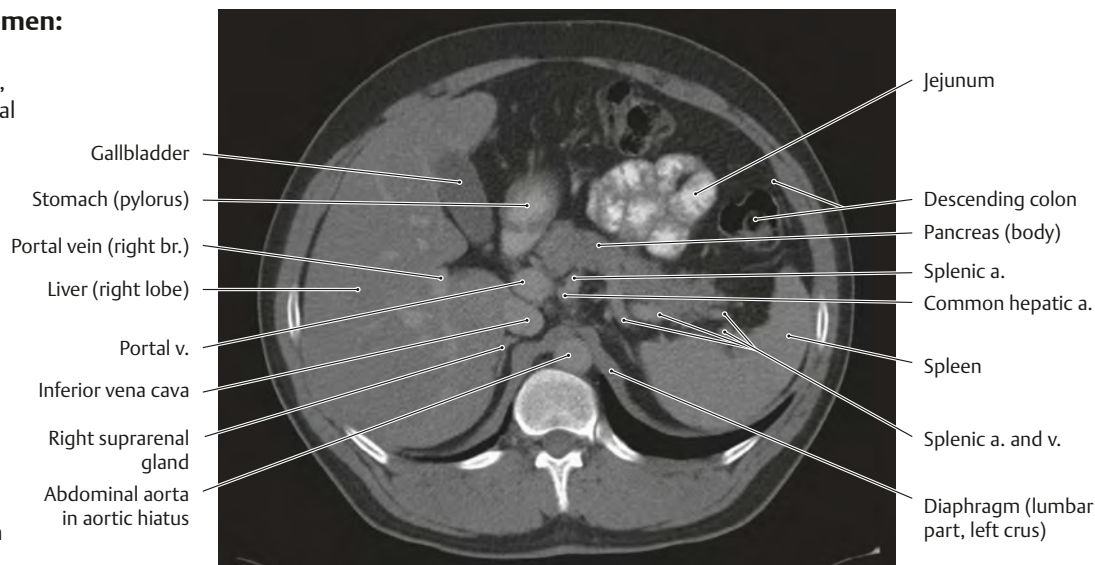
CT of the abdomen:
